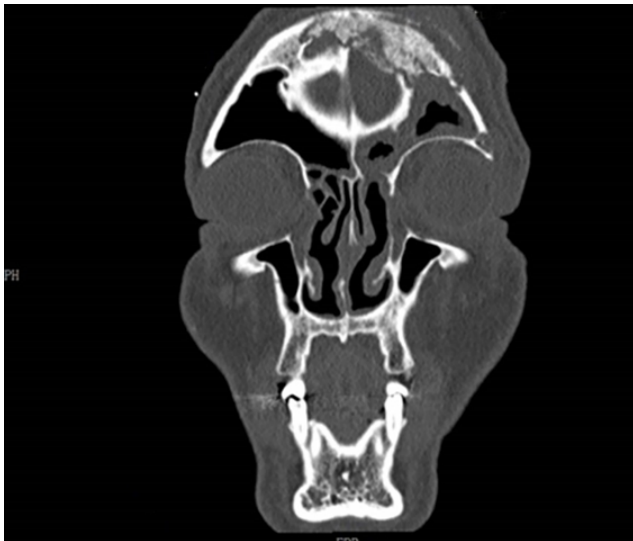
CT scanhead/PNS showing frontal sinusitis with necrotic frontal bone with underlying pachymeningitis
